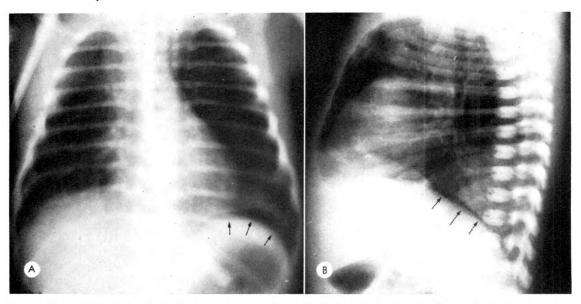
Case II. (A) Frontal chest roentgenogram shows the crescentic gas lucency (arrows) of subpulmonary pneumothorax. (B) Lateral chest roentgenogram shows free intrapleural gas (arrows) beneath the incompletely expanded left lower lobe. The retrosternal lucency is indicative of pneumomediastinum.
